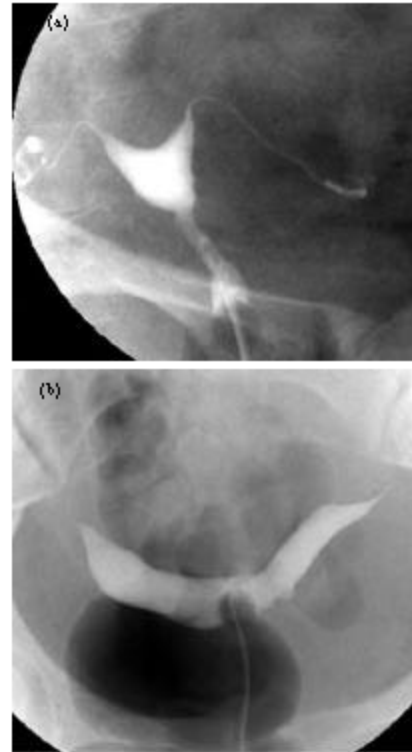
(a) *Bicornuate uterus*. Spot radiograph shows two markedly splayed uterine horns (b) *Arcuate uterus*. Spot radiograph demonstrates a depression of the uterine fundus, a finding that may represent a short septum or an arcuate deformity
